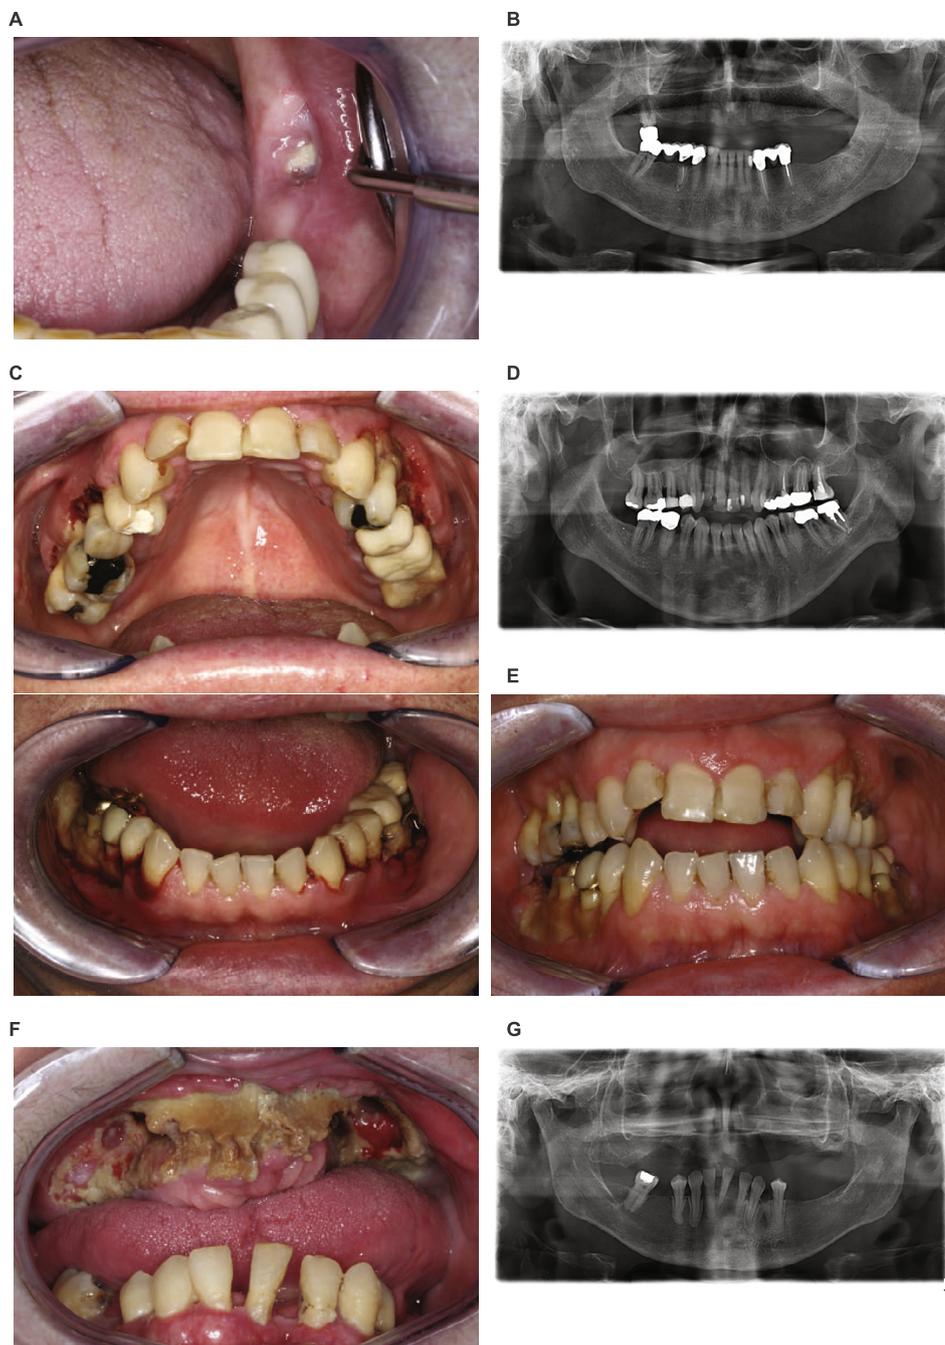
Clinical and radiological images showing examples of MRONJ of the jaw stages 1–3. Stage 1: man aged 78 years with multiple myeloma who had received pamidronate 90 mg IV every 4 weeks for 2 years. (A) Intraorally exposed necrotic bone was present in region 38 of his left mandible with no signs of infection; the patient was not experiencing any pain. The lesion corresponds to stage 1 MRONJ according to AAOMS 2014 criteria. (B) Panoramic radiograph of the patient showing a persisting alveolar socket in region 38, with surrounding sclerotic changes. Persisting alveolar sockets can also be detected in the maxillary incisor area. Stage 2: man aged 59 years with multiple myeloma who had received zoledronic acid 4 mg IV every 3–4 weeks for more than 2 years. (C) Stage 2 MRONJ lesions are visible on both sides of the mandible and both sides of the maxilla. The patient experienced pain and had severe signs of infection, particularly bleeding, swelling and halitosis. The areas of MRONJ reflect the areas of pre-existing lesions from marginal periodontitis. (D) Panoramic radiograph of the patient with areas of horizontal and vertical bone loss in the molar and premolar regions of both sides of the mandible and maxilla, with only mild sclerotic changes. In addition, radio-opacities are visible in both maxillary sinuses and in the teeth-bearing areas at sites of restorative and prosthetic dentistry. (E) Signs of infection were reduced after 2 weeks of antibiotic treatment. Stage 3: woman aged 71 years with breast cancer and bone metastases who had received zoledronic acid 4 mg IV every 3–4 weeks for 4 years. (F) The patient developed stage 3 MRONJ with large areas of bone exposure and pus exudation on both sides of the maxilla, plus a chronic oro-antral fistula formation with pus exudation from the maxillary sinus on the left-hand side. The patient had overt halitosis and ‘spontaneous’ tooth loss (most probably because of severe marginal periodontitis). The patient was receiving strong opioids and therefore did not experience oral pain until very late in the course of her disease; she reported difficulties drinking and had lost fluids through the nose (because of the oro-antral communication on the left side). The oncologist referred the patient to the OMFS because of severe halitosis and pain. (G) Panoramic radiograph of the patient with structural bone loss on both sides of the maxilla and radio-opacities in both maxillary sinuses.
